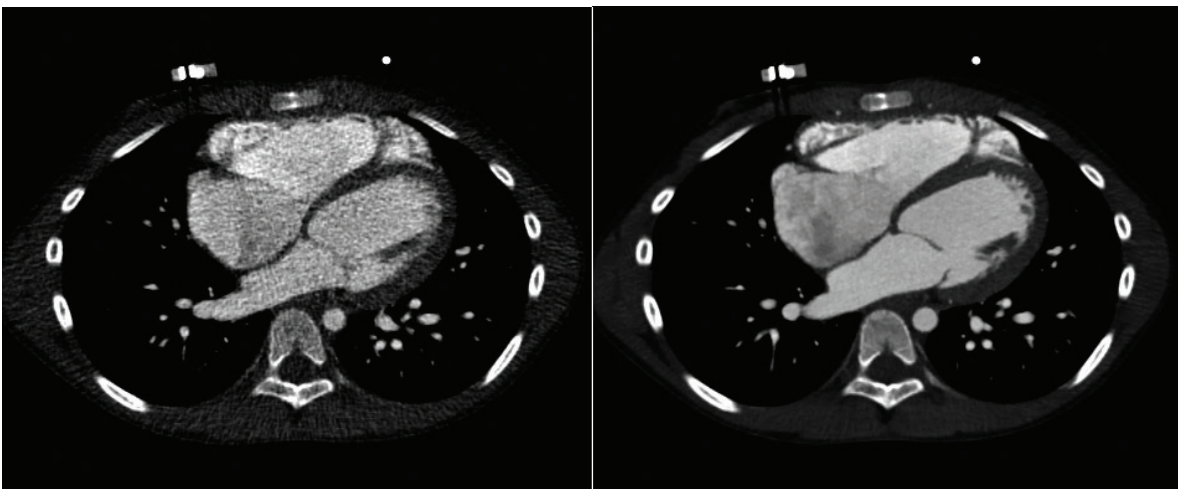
Low dose pediatric heart CT imaging ; Left: standard weighted FBP reconstruction; Right: iterative-based SAFIRE reconstruction [8].
